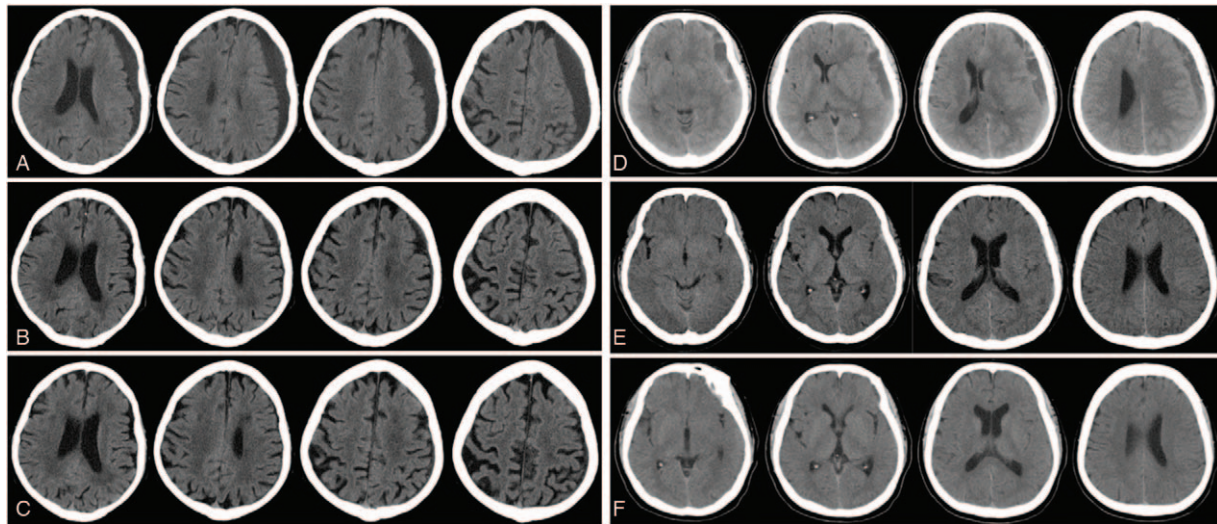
Case 3 (A–C, head computed tomography scan) was an 84-year-old male patient with a recurrent chronic subdural hematoma (CSDH) in left frontal parietal 2 weeks after burr-hole drainage operation. He had a definitive history of head trauma before first CSDH. He suffered from headache, dizziness, and weak limbs, and the score of Markwalder grading scale (MGS) was 2 when enrolled in this study. The hematoma volumes were measured as 99.03 mL (A), 18.86 mL (B), and almost undetectable (C) before, after Chinese herbal medicine (CHM) treatment lasting for 3 months, and in 6 months after CHM treatment termination. Case 39 (D–F, head computed tomography scan) was a 62-year-old female patient who suffered from headache 1 week, with a definitive history of head trauma and MGS 2. She had left frontotemporal subdural hematoma of 77.86 mL (D), with midline shift to right and cerebral hernia. After CHM treatment lasting for 2 months, the hematoma volume reduced to 5.55 mL (E) without midline shift and cerebral hernia, and at the end of CHM treatment, the hematoma was almost undetectable (F).
